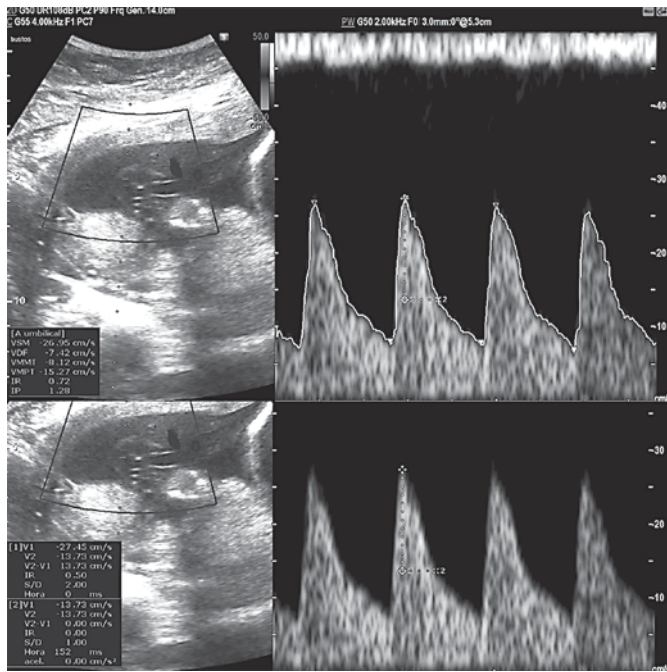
Representative spectral Doppler waveforms in a 29-week fetus with severe FGR show a normal UA PI of 1.28 but an abnormal hPSV-DT of 152 ms. Note the narrow blood flow waveforms. The newborn infant weighed 685 g and survived.
